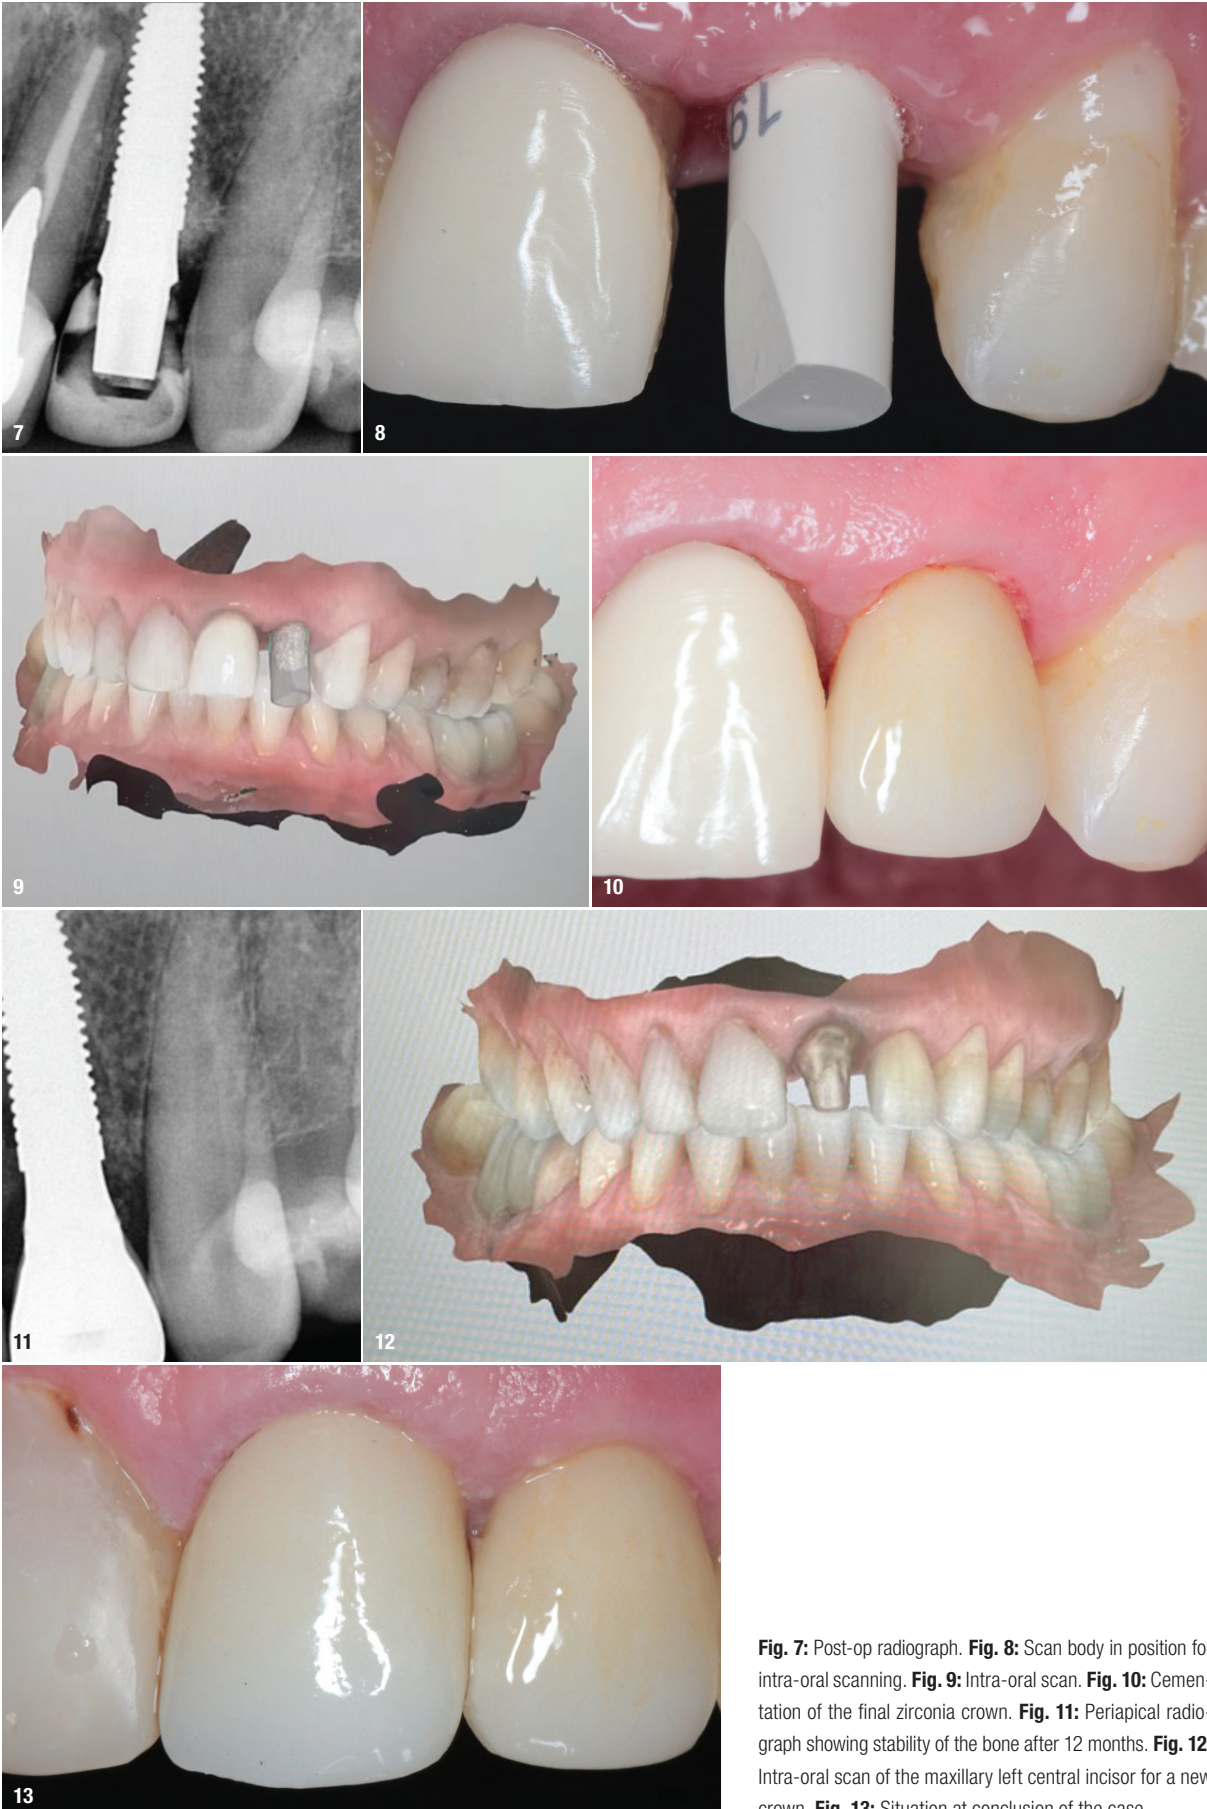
Post-op radiograph. Fig. 8: Scan body in position for intra-oral scanning. Fig. 9: Intra-oral scan. Fig. 10: Cementation of the final zirconia crown. Fig. 11: Periapical radiograph showing stability of the bone after 12 months. Fig. 12: Intra-oral scan of the maxillary left central incisor for a new crown. Fig. 13: Situation at conclusion of the case.
